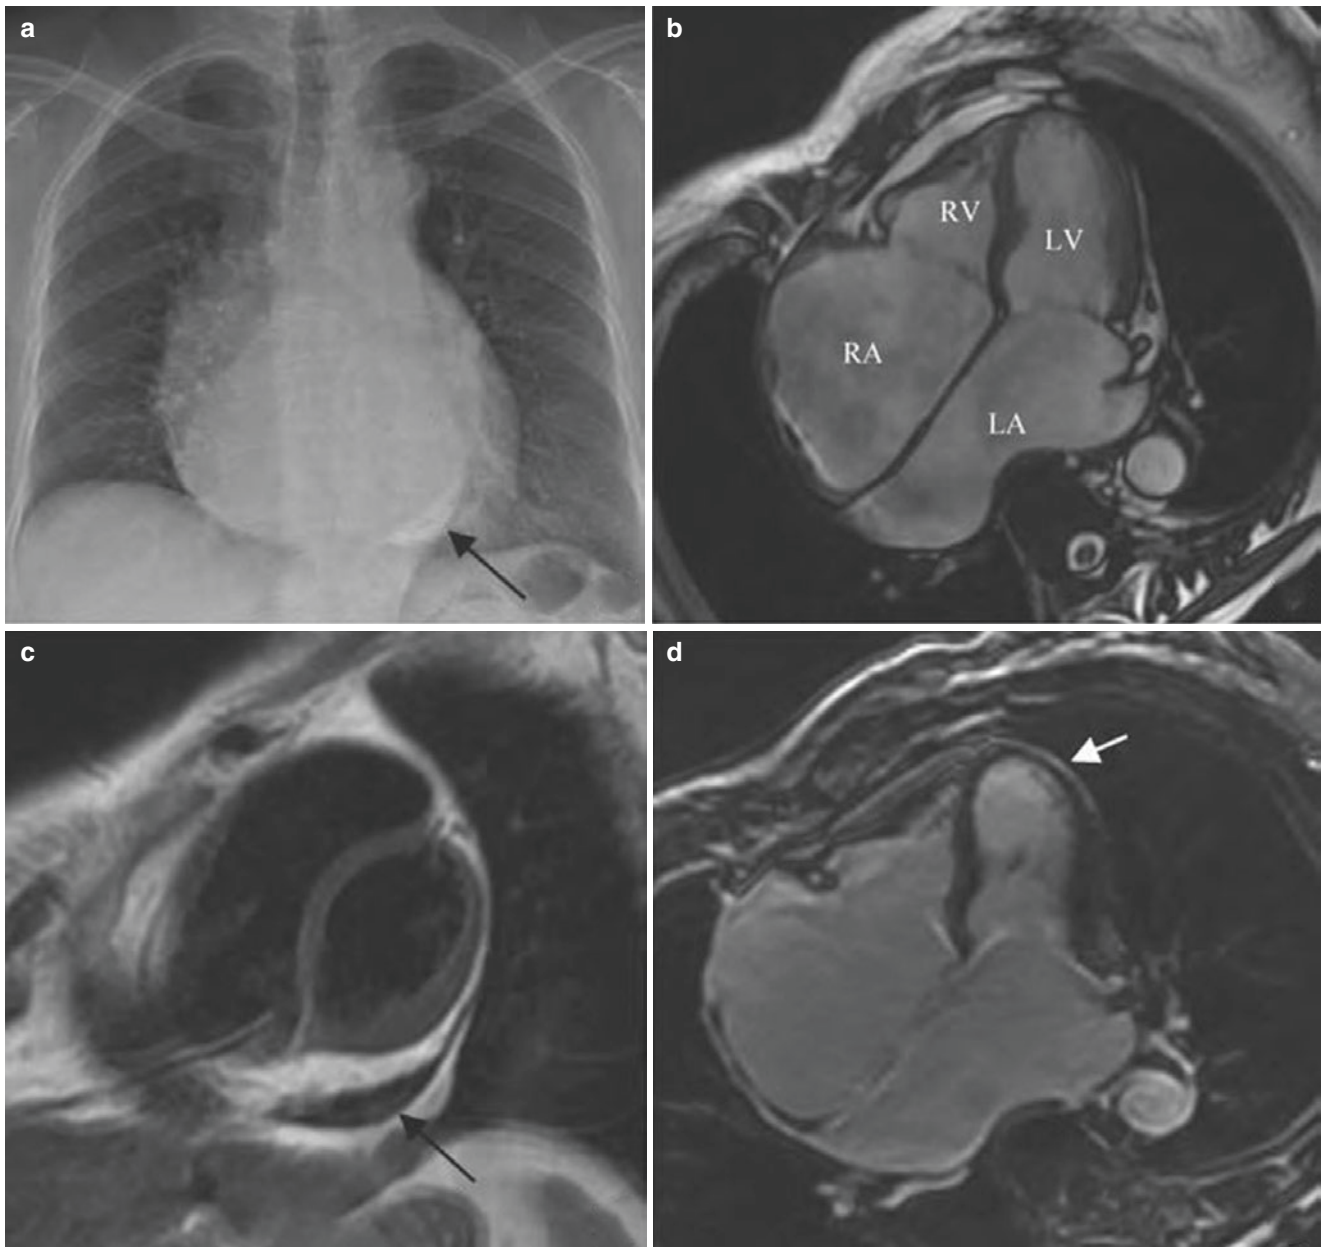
Constrictive pericarditis (II). (a) Chest X-ray showed arcuate calcification of the lower edge of pericardium (arrow); (b) cardiac MRI cine sequence showed that left and right ventricles (LV, RV) were limited in diastole and reduced in volume, and left and right atria (LA, RA) were significantly dilated; (c) black-blood sequence showed
